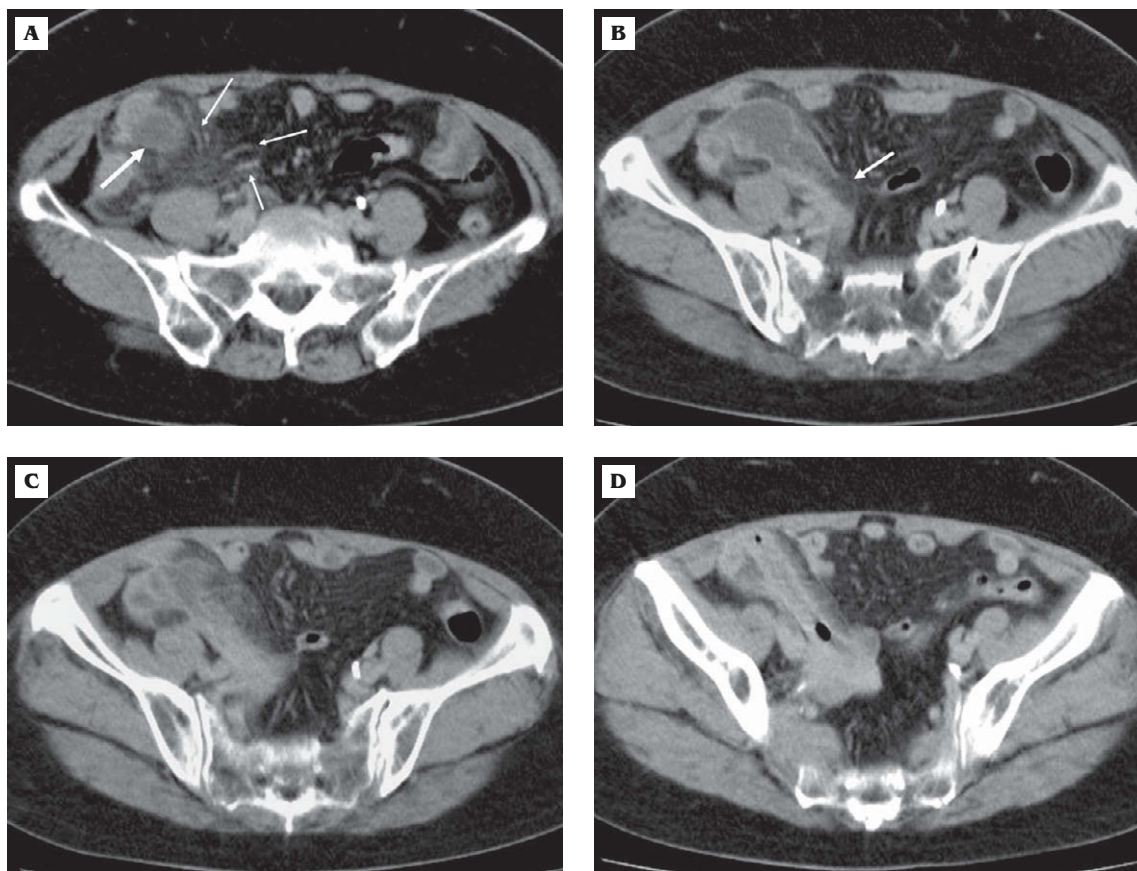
A 72-year-old woman presenting with right lower quadrant abdominal pain caused by a perforated appendiceal mucinous cystadenoma. (A) Post-enhanced CT shows a thin-walled, oval, low-attenuation lesion (large arrow) in the right lower quadrant of the abdomen, associated with a whirled appearance of adjacent mesenteric vessels (small arrows), suggesting possible tumor torsion. (B) CT scan at a level more caudal than panel A shows a low-attenuation lesion arising from the appendiceal orifice, contiguous with the cecal base. There is a focal wall defect (arrow) at its inner aspect, indicating tumor rupture. (C) CT scan at a level more caudal than panel B shows the elongated low-attenuation lesion connecting with the distal part of the appendix, associated with periappendiceal fat stranding. (D) CT scan at the appendix tip level shows the dilated distal portion of the appendix exhibiting abnormal enhanced thickened walls with intraluminal air and fluid content.
